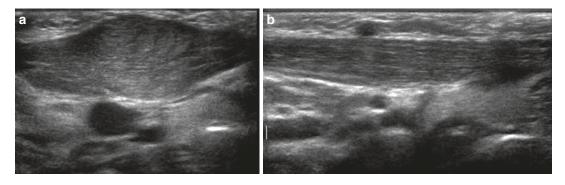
Fibromatosis colli (benign sternomastoid tumour of infancy). Longitudinal grey scale ultrasound image of the sternomastoid shows a smooth fusiform
